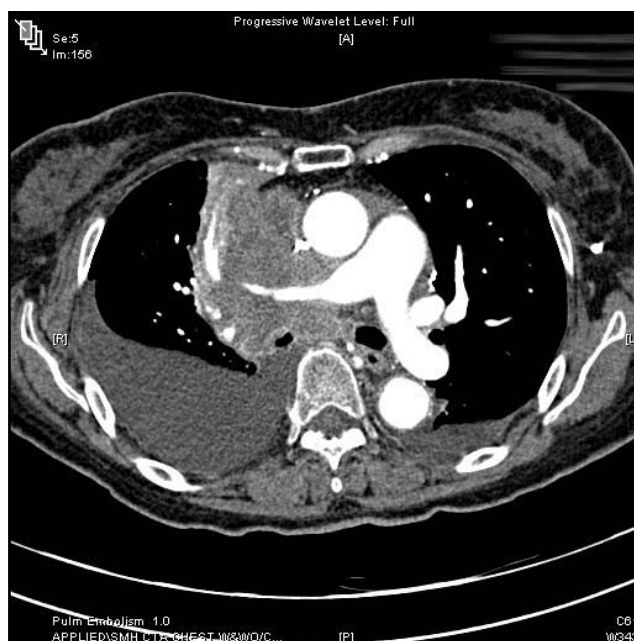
CT angiogram of the chest
